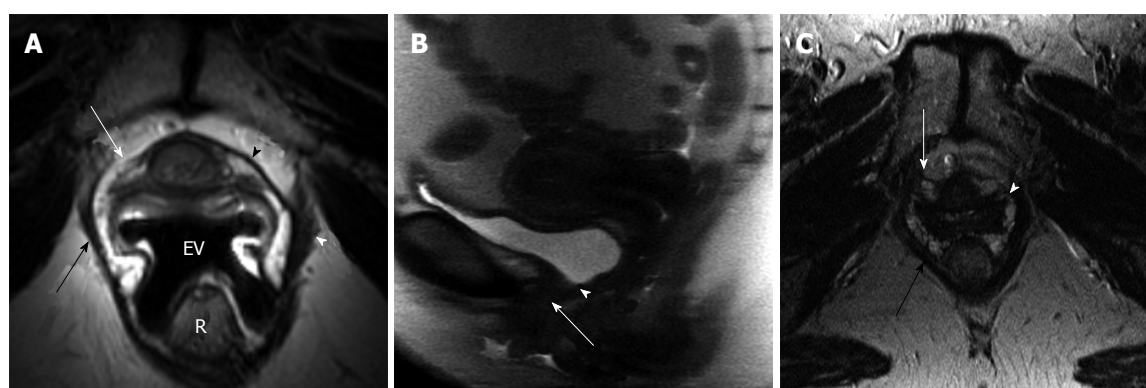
51-year-old woman post two uneventful vaginal deliveries, body mass index: 24.3. A: Axial oblique T2-weighted image at the mid urethra level (at 50% length from the internal meatus, about 1.2 cm), perpendicular to the axis of urethra, obtained with endovaginal placement of MRInnervu coil (EV) (TR/TE 3200/93 ms) shows disrupted attenuated right periurethral ligament (white arrow). Note intact left side of the periurethral ligament (black arrowhead) and its attachment to the puborectalis muscle (white arrowhead). Minimal asymmetric thinning of the right puborectalis muscle (black arrow); B: Sagittal SSFSE image (TR/TE 15000/78 ms) during strain shows hypermobility of the urethra (arrow). Note closure of bladder neck (arrowhead) during the urethral descent; C: Axial T2-weighted image of the pelvis at the level of mid urethra (at 50% from the internal meatus) obtained with pelvic coil (TR/TE 4666/85 ms) shows much less detail of the periurethral ligament compared to endovaginal MRI in A. It is difficult to appreciate the status of the ligament itself (white arrow) or its attachment (white arrowhead). Puborectalis muscle (black arrow) is well visualized. R: Rectum.
